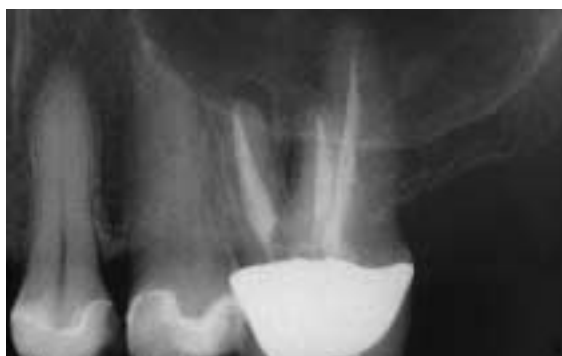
Diagnostic radiograph of tooth 26 before retreatment.
